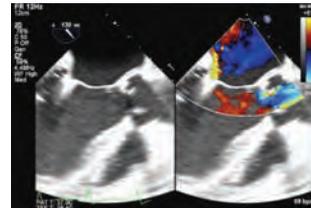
Transesophageal echocardiography demonstrates a part of calcified papillary muscle attached via chords to the anterior mitral valve leaflet moving like a whip in the left atrium during systole.
